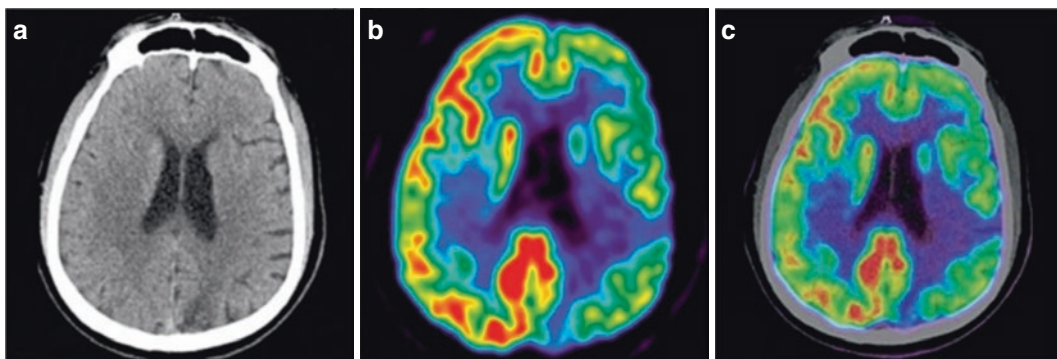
Left intracranial artery stenosis. A 60-year-old male patient. Transverse head CT plain scan shows foliate hypodense shadows in the left parietal lobe (a). Transverse ^{18}F -FDG PET (b) and integrated ^{18}F -FDG PET/CT (c) show impaired ^{18}F -FDG uptake of the left
